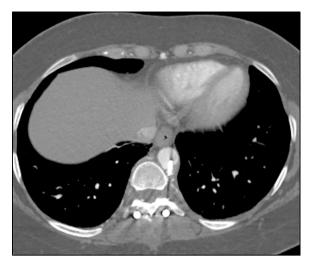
CT angiogram showing transpedicular screw perforation of the aorta.
